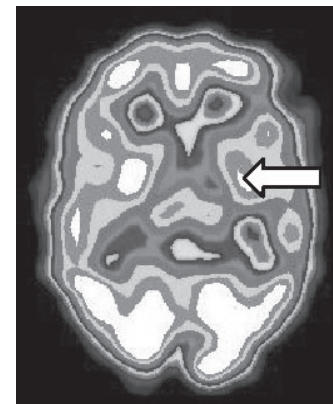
SPECT scan of the same patient showing improvement in perfusion following six weeks treatment with piracetam.
